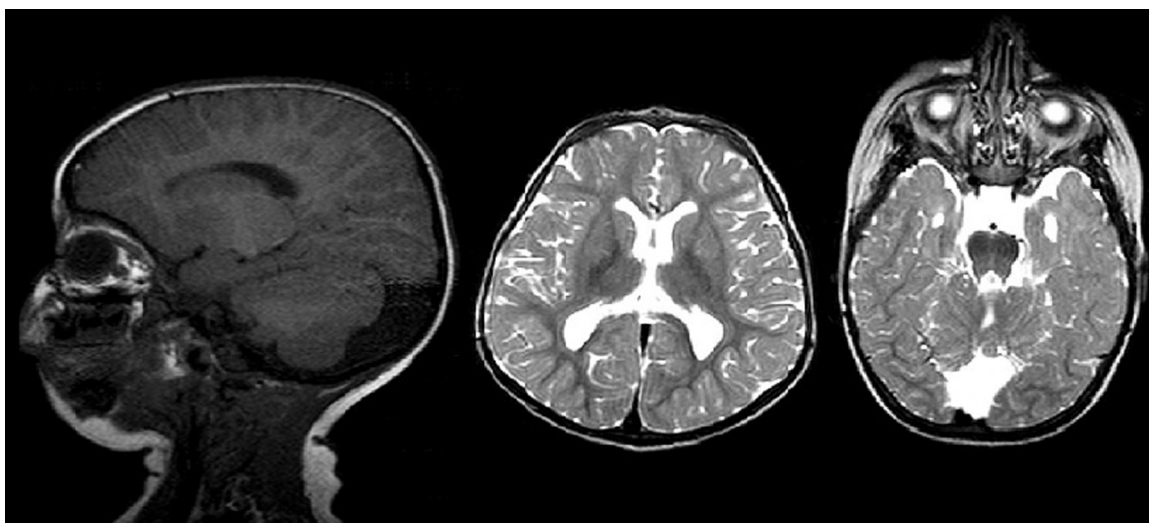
Brain MRI image of our patient.
